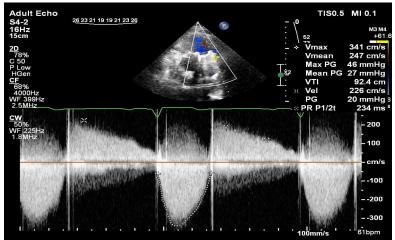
Doppler study of mechanical pulmonary valve malfunction shows increased MPG (27 mm Hg) and PPG (46 mm Hg) and moderate transvalvular regurgitation (pressure half-time [PHT], 234 ms).
